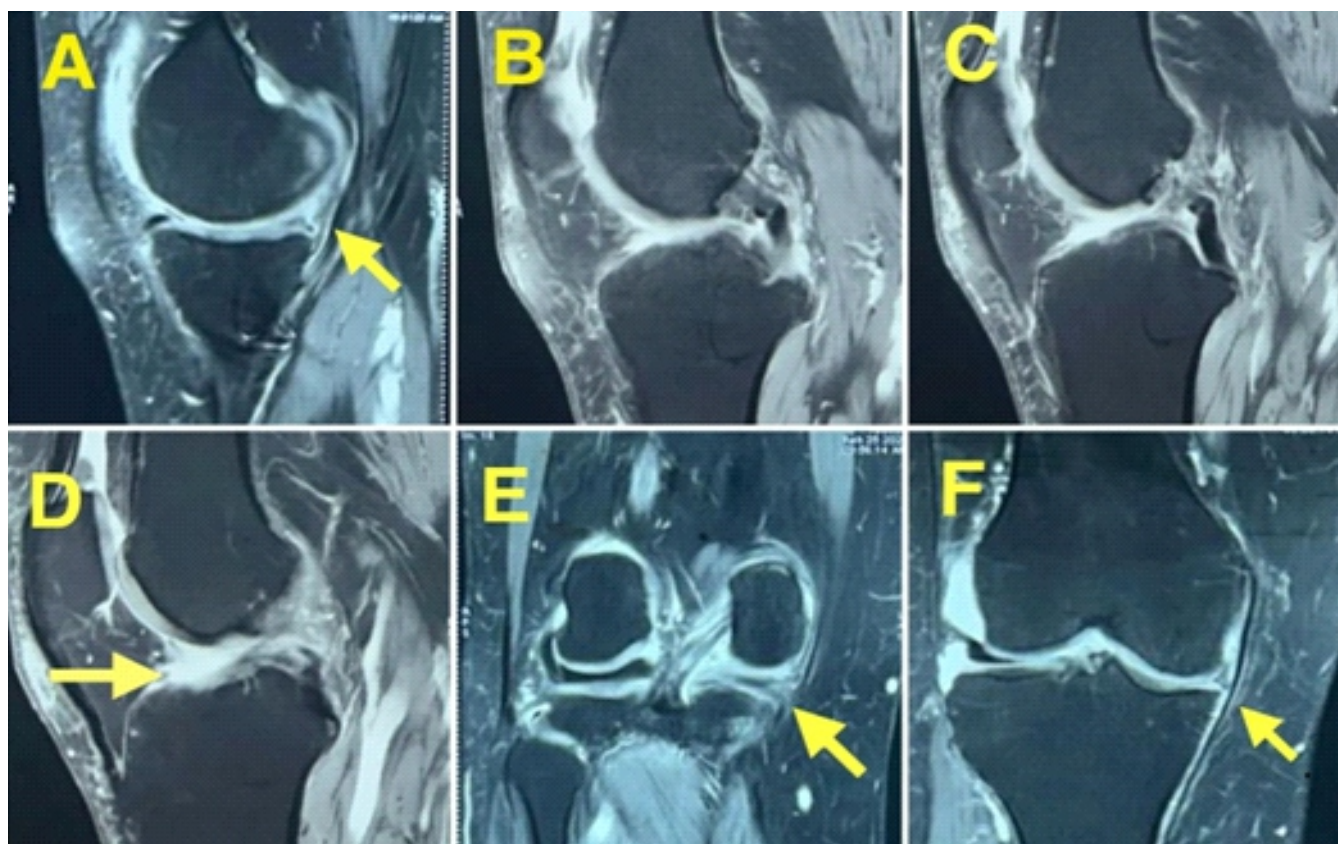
Magnetic resonance imaging showing complex tear of medial meniscus with an anterior cruciate ligament tear.
